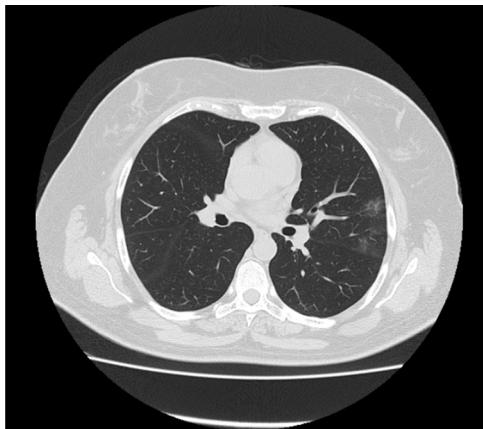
Chest computed tomography (CT) image in first day of hospitalization. The image demonstrates two ground glass opacities in peripheral area of left upper lobe. The patient had few bilateral, peripheral ground glass opacities.
